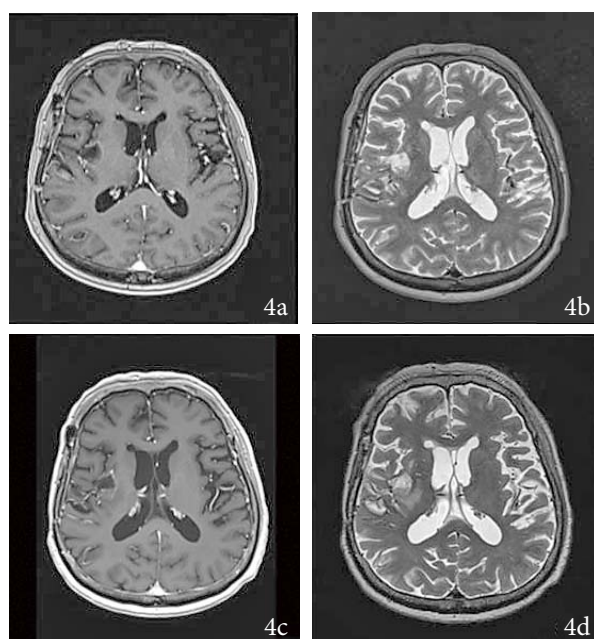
Three months (4.a) and seven months (4.c) after surgery and Gamma Knife Radiosurgery - axial contrast-enhanced T1-weighted MR image showing a significant reduction of the tumor volume. Three months (4.b) and seven months (4.d) after surgery and Gamma Knife Radiosurgery - coronal T2-weighted MR image showing no signs of perifocal edema surrounding the operative cavity.
